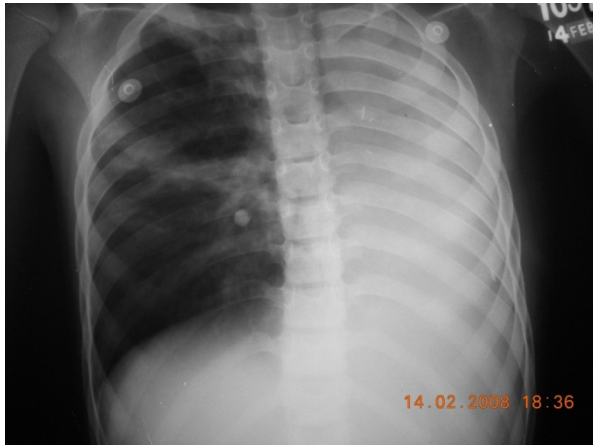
Post operative chest radiograph showing opacity in Right lung field
